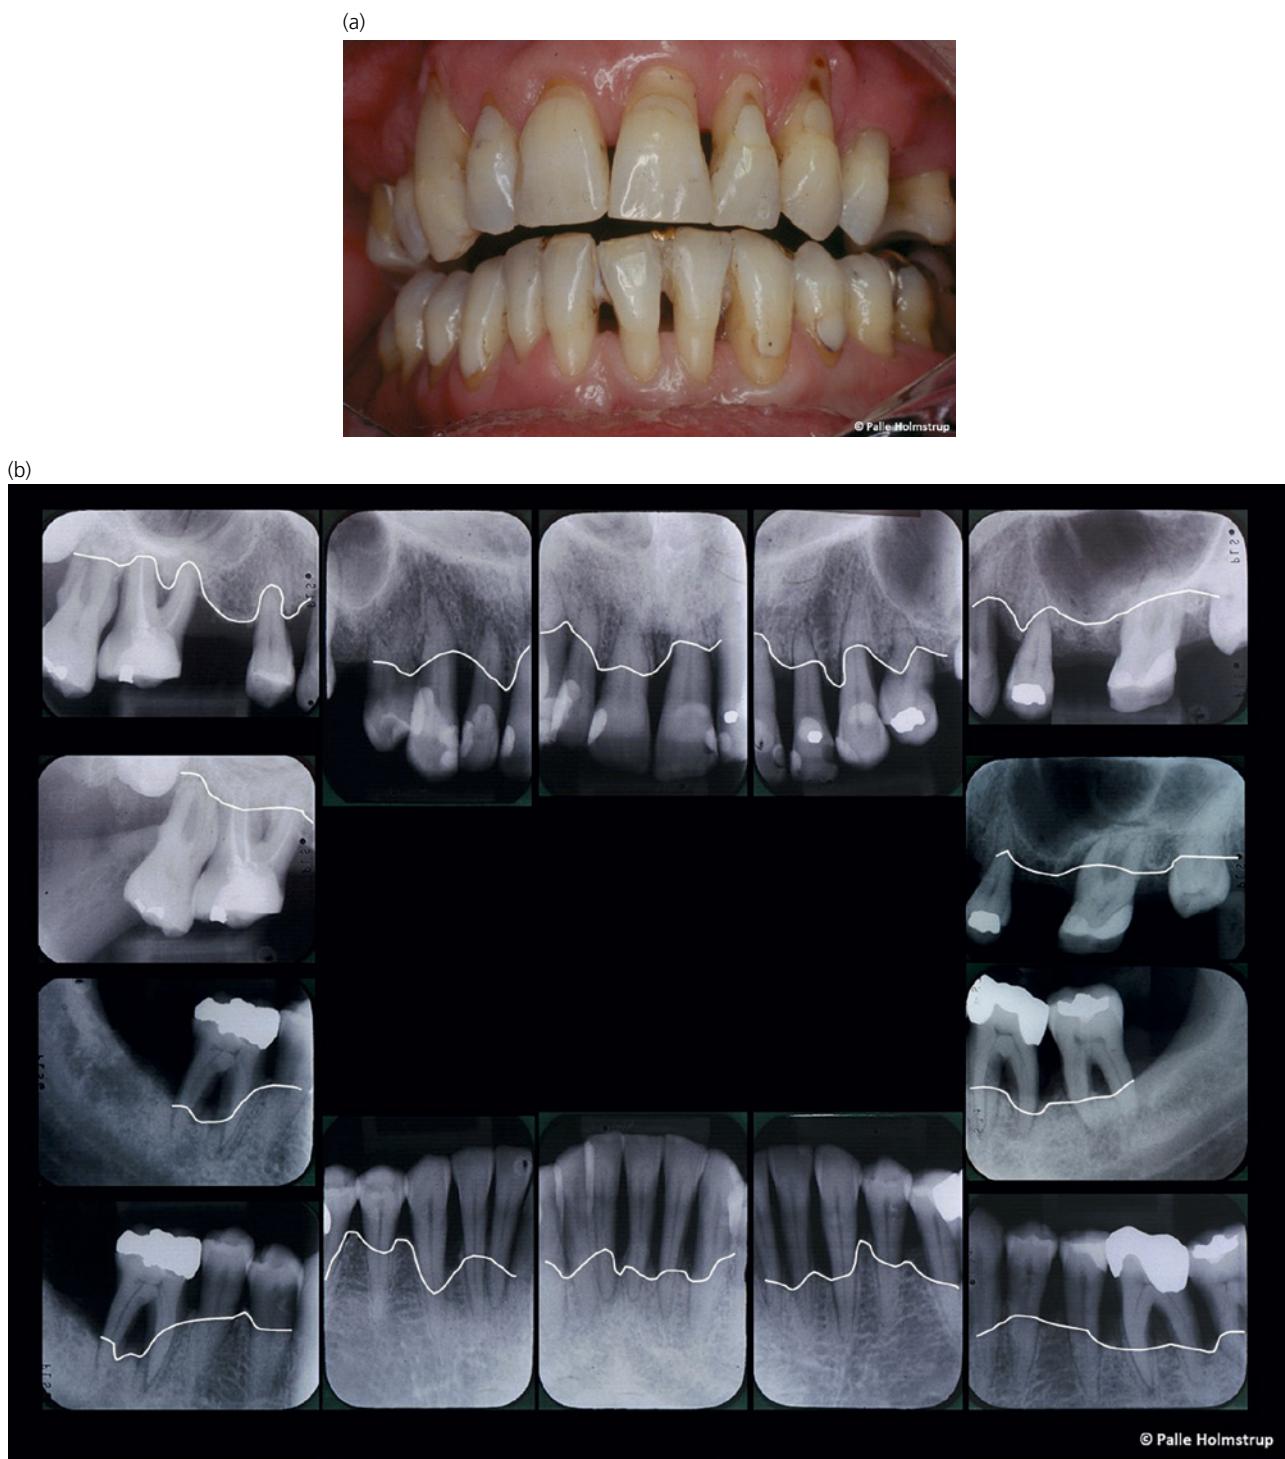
(a) A 47-year-old person with severe periodontitis causing elongated teeth due to loss of tooth-supporting tissue. (b) The same person as in (a). X-rays demonstrate major loss of alveolar bone due to severe periodontitis. Margin of bone marked with white line. While the pristine level of the bone margin is approximately 2 mm from the crown of the teeth, the supporting bone around several teeth is limited to the periapical part of the root.
